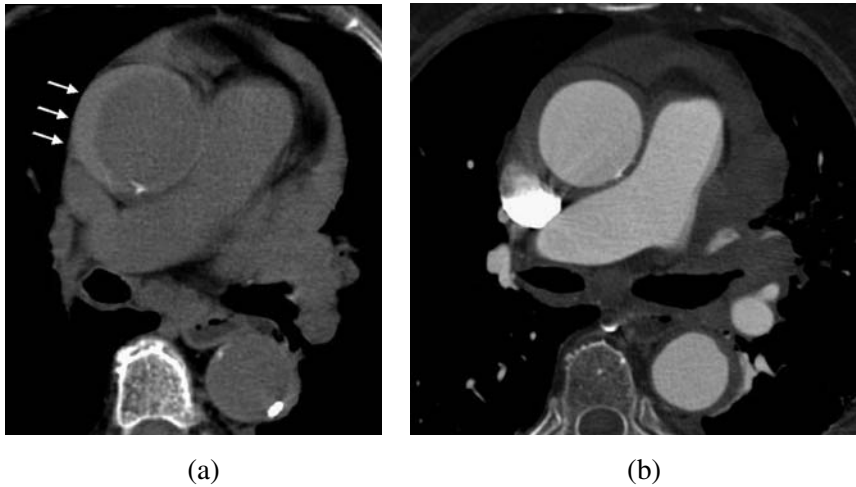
Intramural hematoma (IMH) is diagnosed on the unenhanced CT scans on the basis of the identification of a crescent-shaped area of attenuation in the aortic wall, corresponding to the hematoma, such as in this example of type A IMH ((a), axial scan, arrows). This area does not show contrast enhancement after contrast material injection ((b), axial scan), and no intimal tears are visualized. Therefore, the unenhanced scans are required for the diagnosis.
